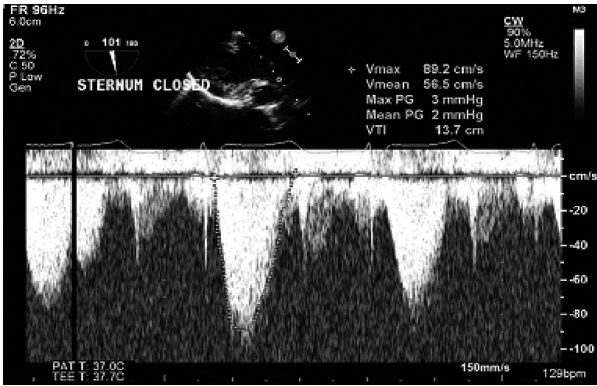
CW Doppler VTI measurement through a normal aortic valve in a transgastric long-axis view; multiplane angle 101°.
